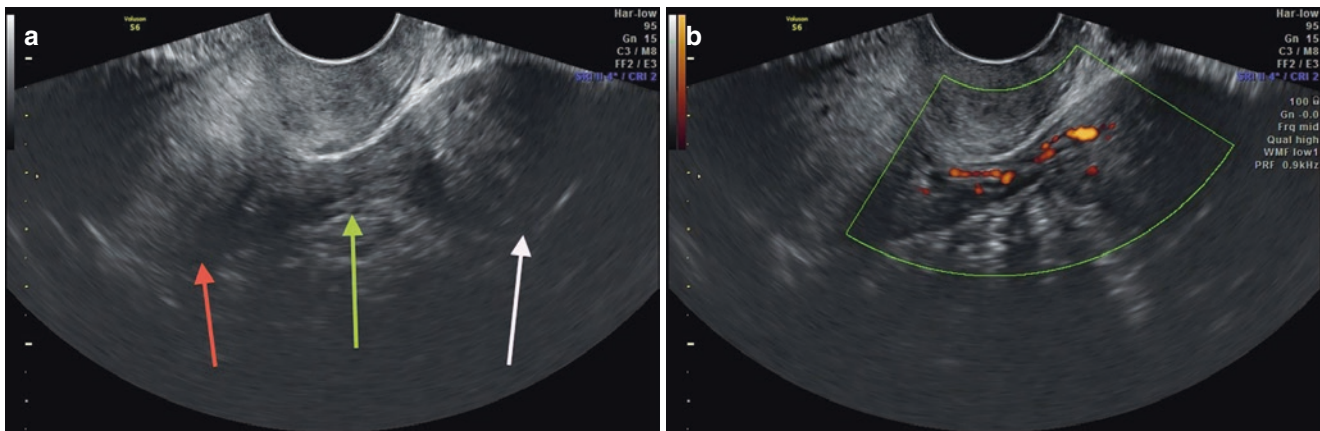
(a) Axial ultrasound section, showing uterine body (*red arrow*), pedicle myoma in the left adnexal region (*white arrow*) and its respective pedicle (*green arrow*). (b) Power Doppler showing vascularization in vascular pedicle of the myoma
